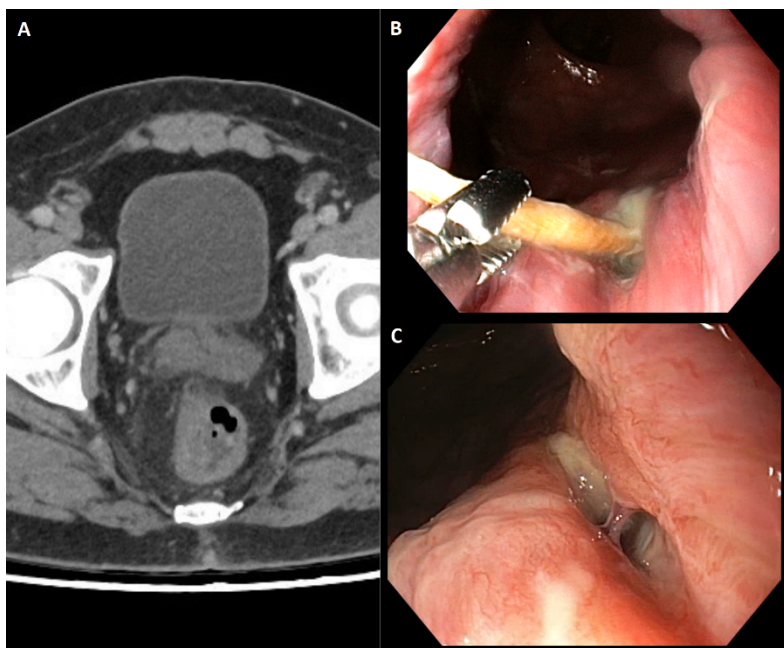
A. Pelvic computed tomography (CT) contrast-enhanced findings: signs of proctitis (rectal wall thickening, pericolic fat stranding and free fluid) and rectal ulcer. B. Toothpick embedded in mucosa and underlying ulcer. Extraction with forceps. C. Deep anorectal ulcer.
